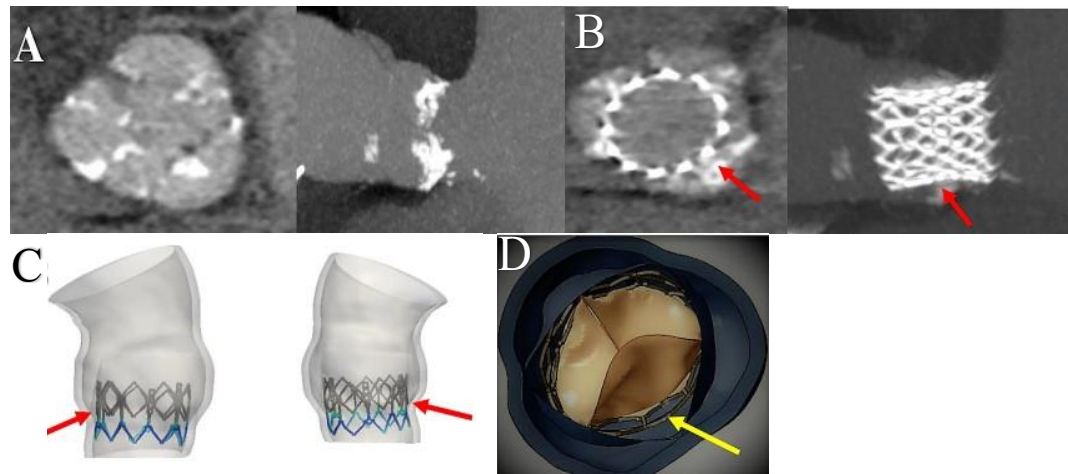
Depict preoperative (A) and postoperative (B) 3 D CT scan with TAVI thrombosis. (C) Biomodeling of a Sapien XT reveal an incomplete deployment (red arrow) of the device with PAVR and thrombotic formation (red arrow). (D) The yellow arrow disclose a the distortion of the stent and reduced mobility of the leaflet of the bioprosthesis in correspondence of a PAVR. Abbreviation; PAVR, paravalvular aortic regurgitation. Other abbreviations in previous figures
